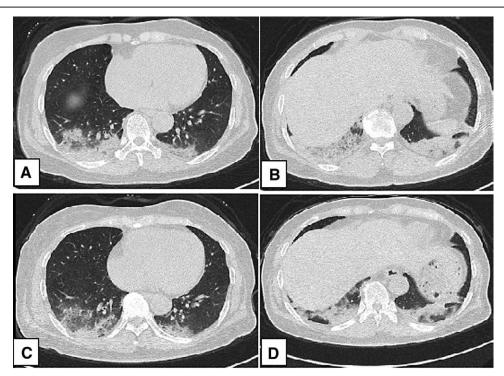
Case 2. On the second day of admission (9 days after onset), chest computed tomography demonstrated patchy consolidation and linear opacities in the bilateral lungs, mainly in both lower lungs (A, B). The lung lesions were greatly absorbed at 70h after the plasma treatment (C, D).
